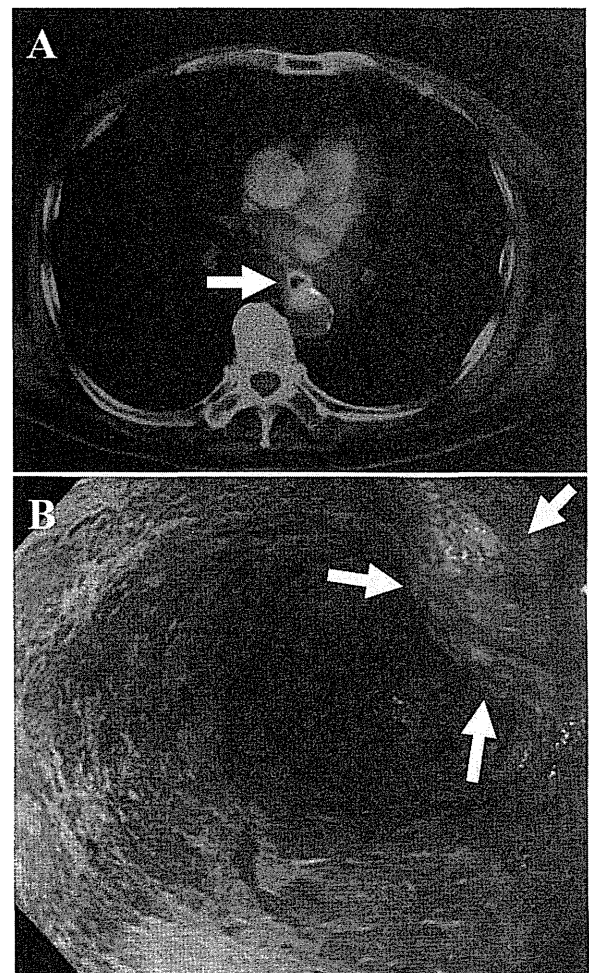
症例 1 の PET/CT および内視鏡画像
